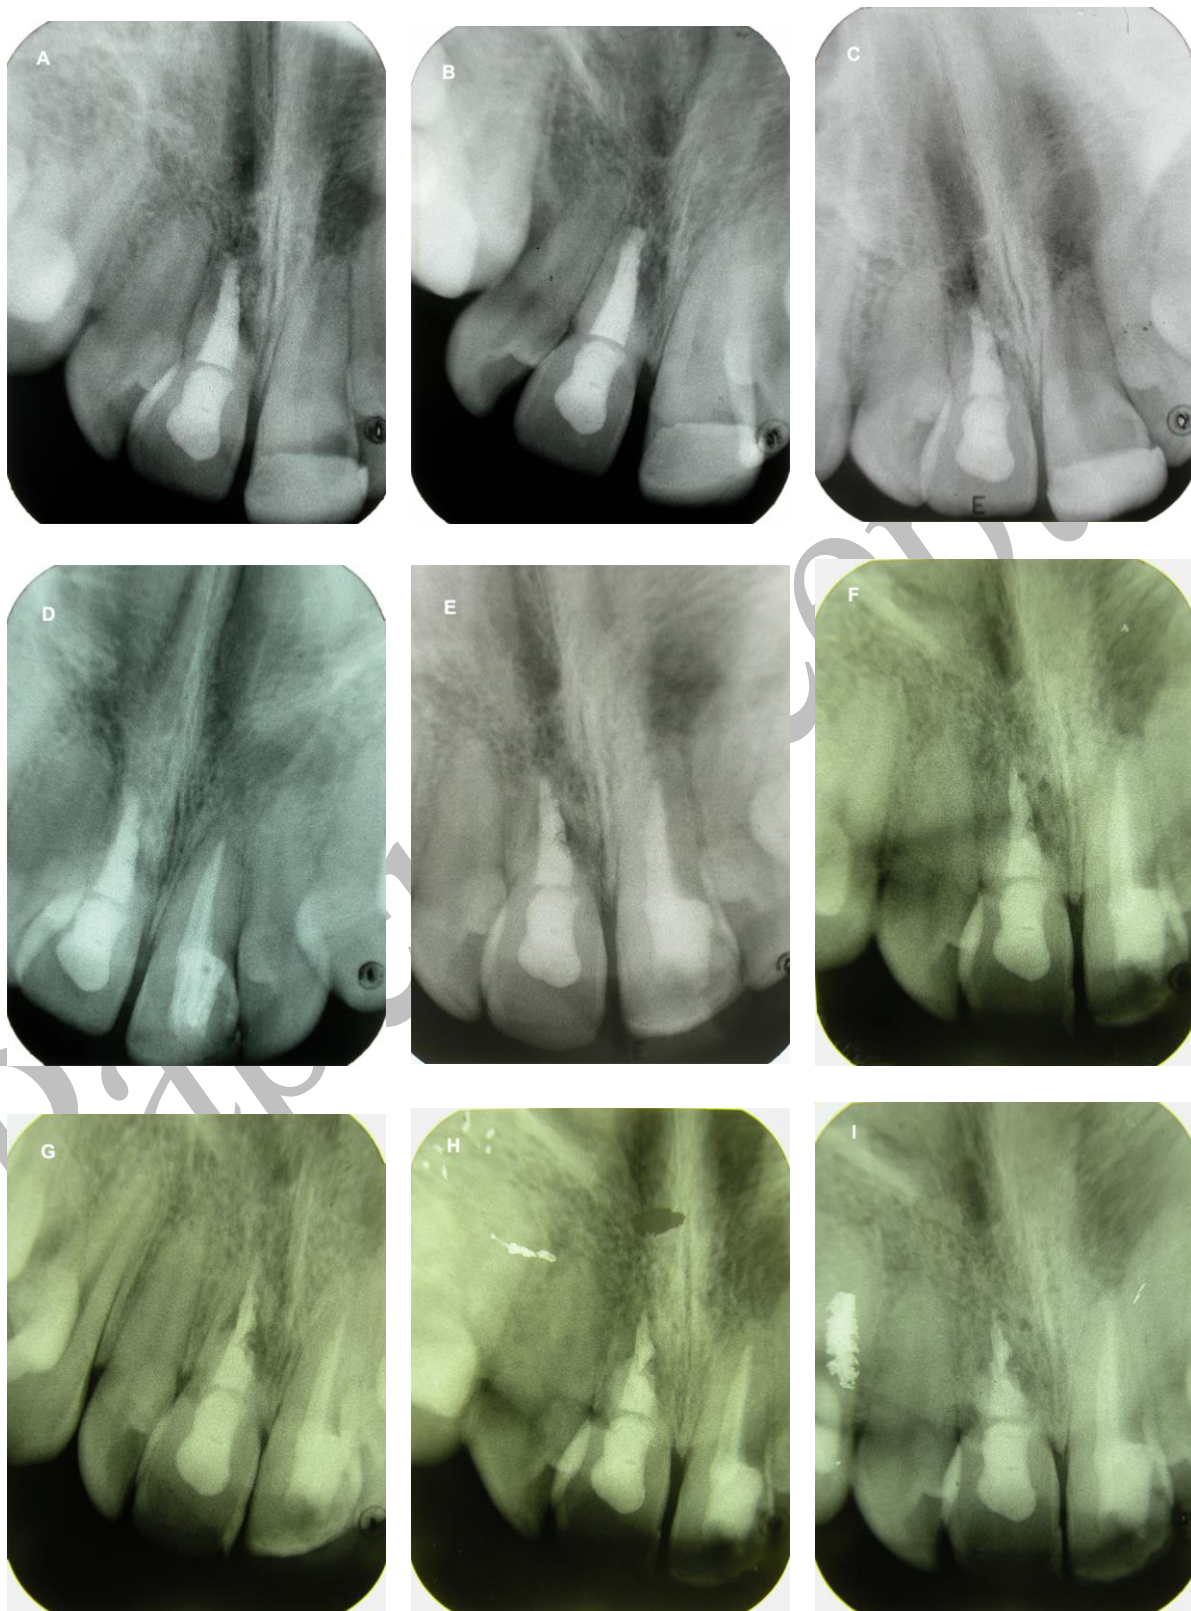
Radiographic follow-up after: (A) 2 years, (B) 3 years, (C) 4 years, (D) 5 years, (E) 6 years, (F) 7 years, (G) 8 years, (H) 9 years, and (I) 10 years
